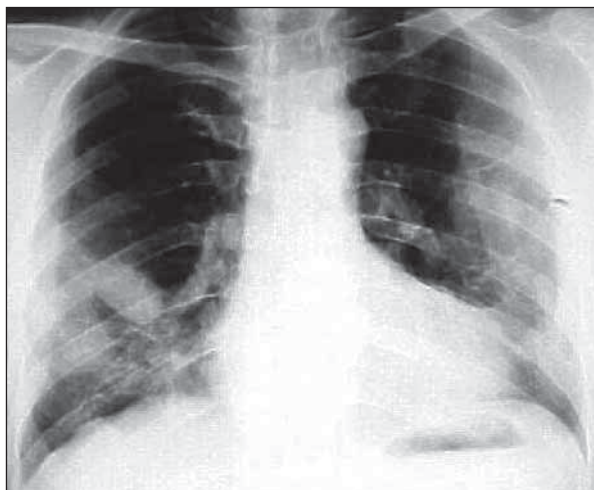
The chest radiograph demonstrating bilateral large pleural opacities and a well-defined opacity in the right middle zone of the lung
